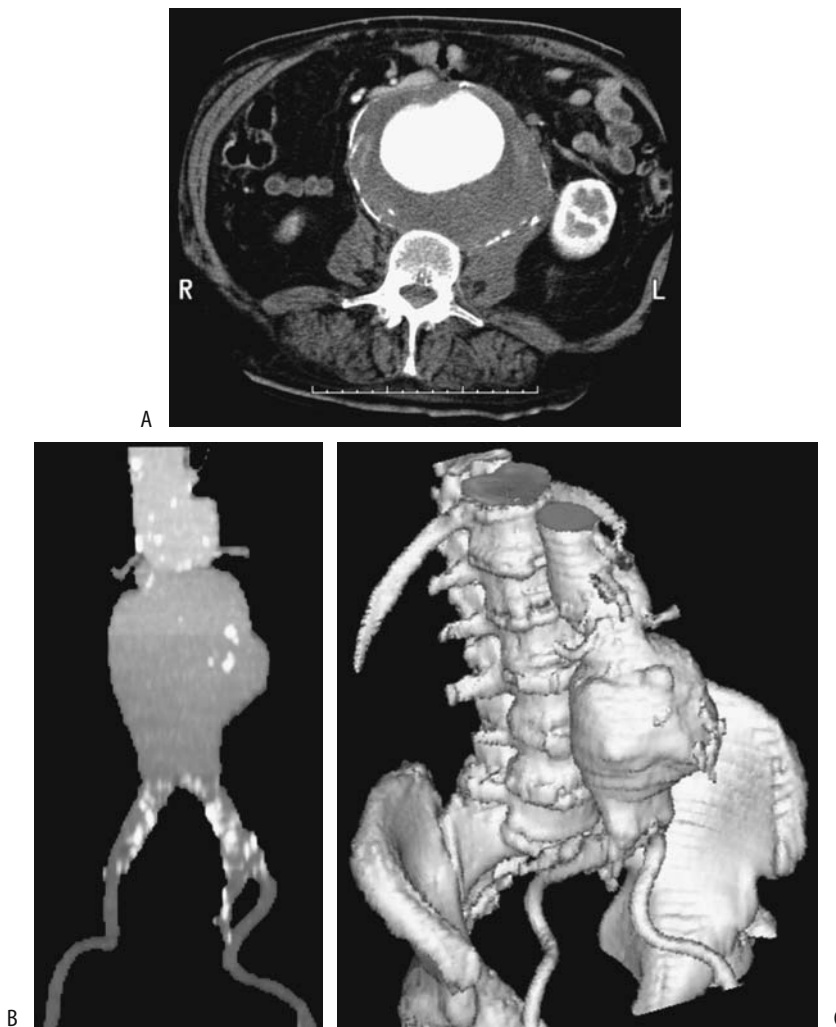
Dissecting abdominal aortic aneurysm. Transverse (A), coronal (B), and 3D (C) CT reconstructions each provide slightly different information about the shape and scope of this aneurysm. (Courtesy of Patrick Fultz, M.D., University of Rochester.)
